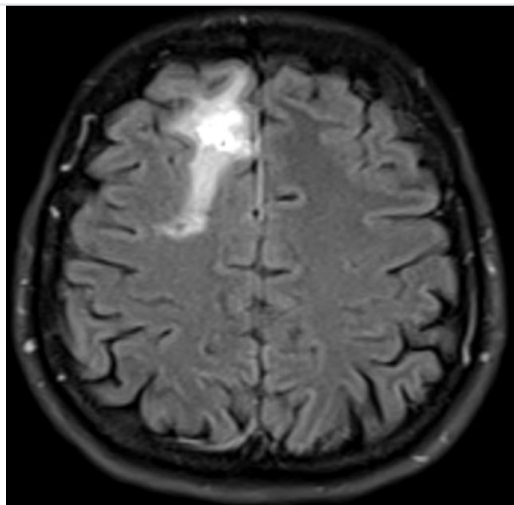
Axial T1 weighted FLAIR magnetic resonance image after biopsy
